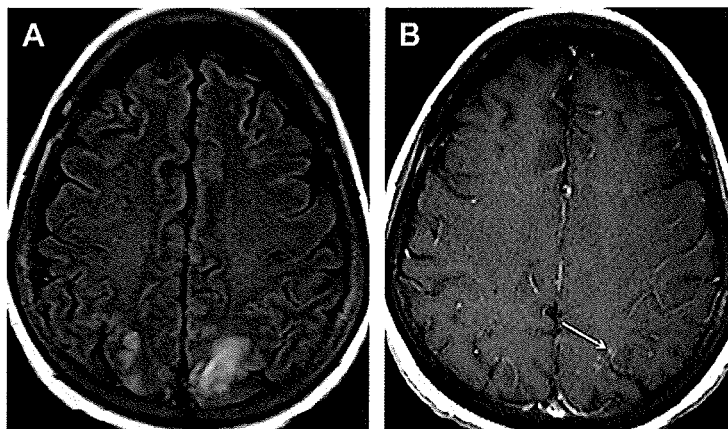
PRES with enhancement. Axial FLAIR image (A) demonstrates FLAIR hyperintensity in the cortex and subcortical white matter of the parietal lobes bilaterally. Postgadolinium axial T1-weighted image (B) shows stippled cortical and subcortical enhancement (arrow) in the area of FLAIR hyperintensity in the left parietal lobe.
